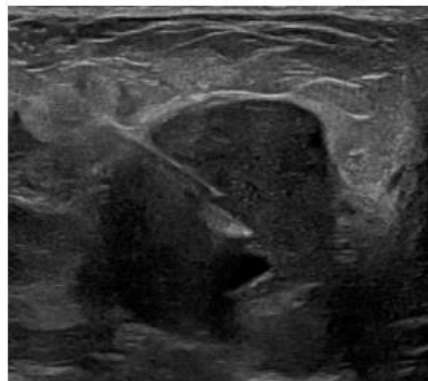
Ultrasound image of the micro-biopsy of the mass
